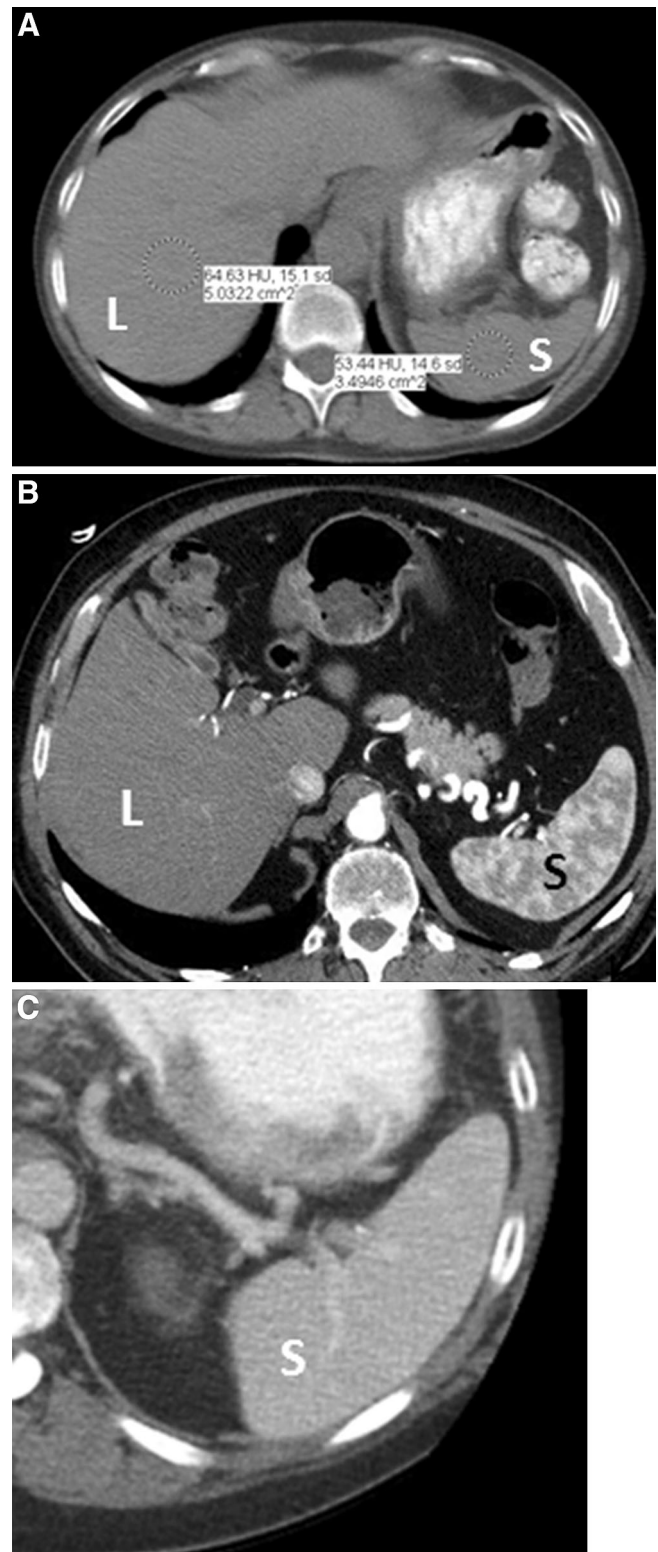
Normal CT appearance of spleen. A Axial unenhanced CT shows the spleen (S), which is usually 40–60 HU in attenuation (53 HU in this case) and 5–10 HU less than the liver (L). B Axial contrast-enhanced CT in arterial phase (35–40 s) shows the arciform pattern of enhancement of the spleen (S). C Normal venous phase appearance of the spleen (S).
